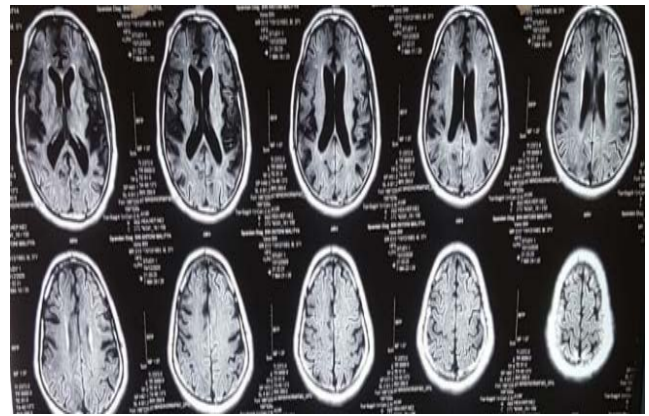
T2 FLAIR showing diffuse sulcal hypo intensity suggestive of Superficial siderosis
